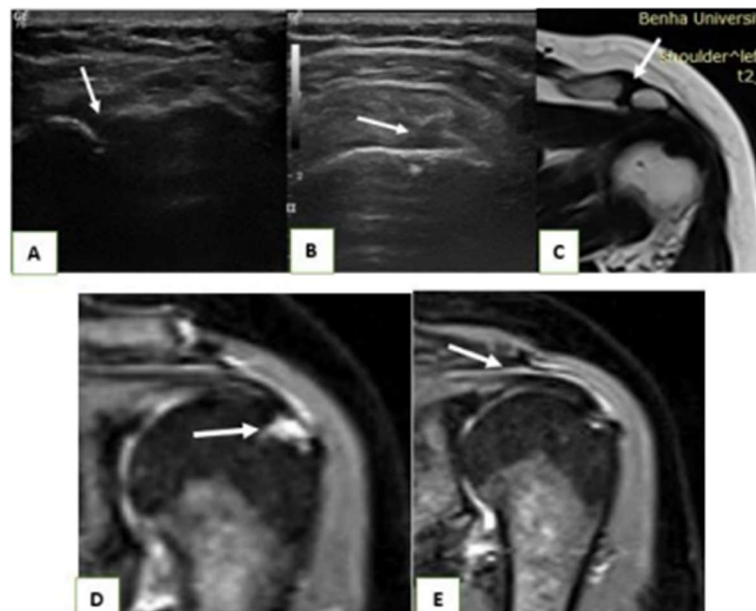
A: The ultrasound picture indicated the presence of AC osteoarthritis (arrow). Ultrasound of the shoulder revealed a partial thickness rip of the supraspinatus tendon on the articular surface, as indicated by a focal
